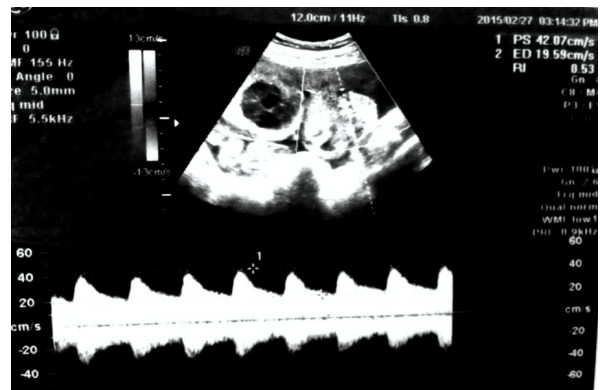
Doppler parameters of the solid components shows, PS=42.07 cm/s, ED=19.59 cm/s, RI=0.53, PI=0.71
